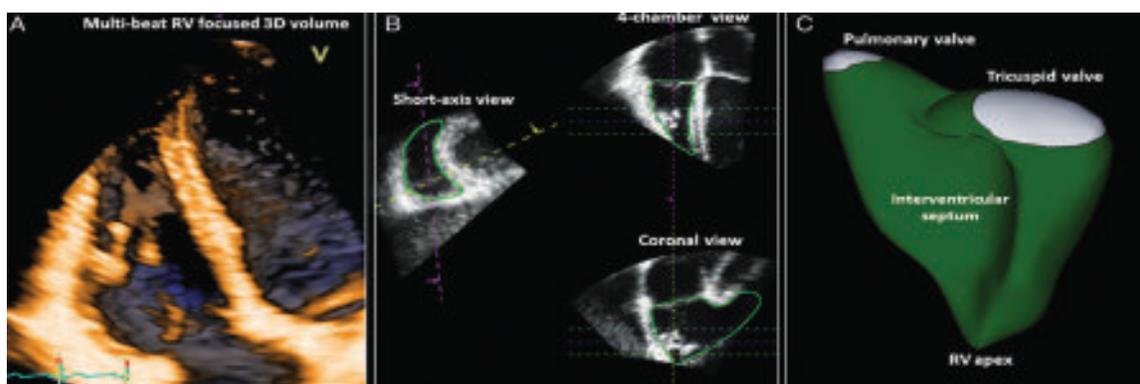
Three-dimensional analysis of the right ventricle (RV). (A) A 3D data set is acquired from a right ventricular-focused apical four-chamber view by stitching together the sub-volumes generated from several (four to six) consecutive beats. (B) The right ventricular endocardial surface is semi-automatically identified after manual initialization in the right ventricular short-axis, four-chamber, and coronal views in both end-systole and end-diastole. (C) The generated 3D surface model of the RV enables the quantification of right ventricular ESV and ESV, stroke volume, and EF.
